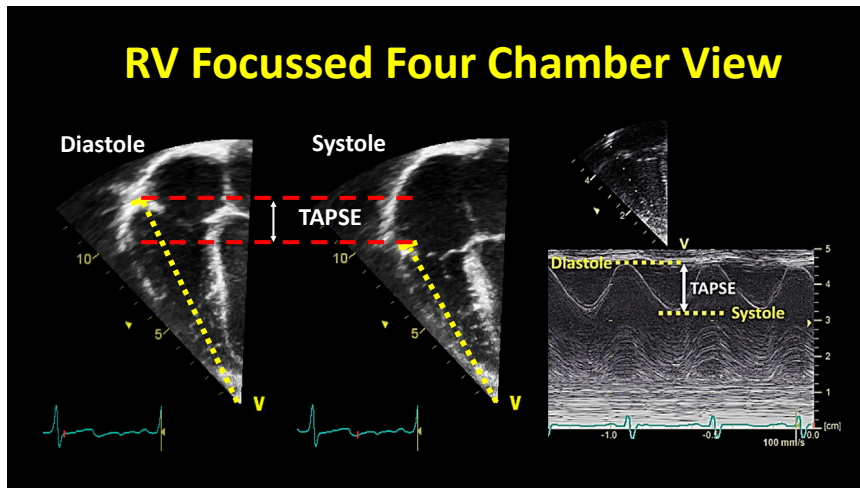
TAPSE measurement from the apical four-chamber view.
